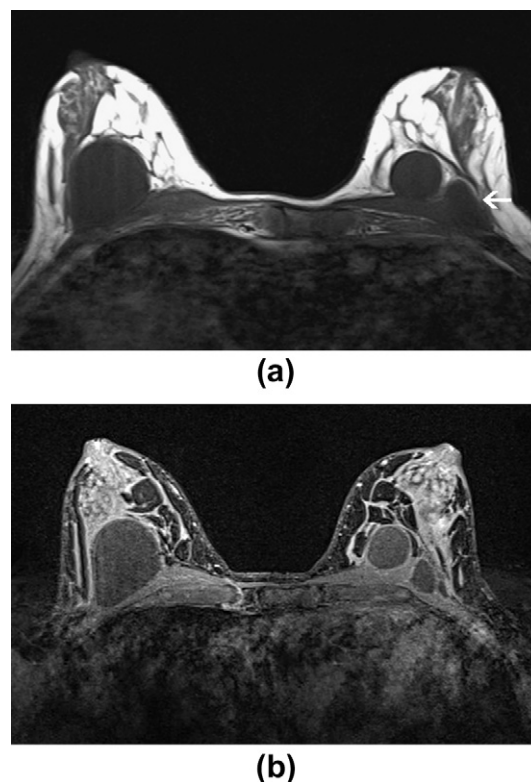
(a) Axial, T1-weighted and (b) T1, fat-saturated post-gadolinium enhancement sequences demonstrate larger collections of Macrolane within the breast parenchyma and pectoralis muscle (arrow). Deposits are low signal intensity on T1 with minimal rim enhancement post contrast medium administration.
